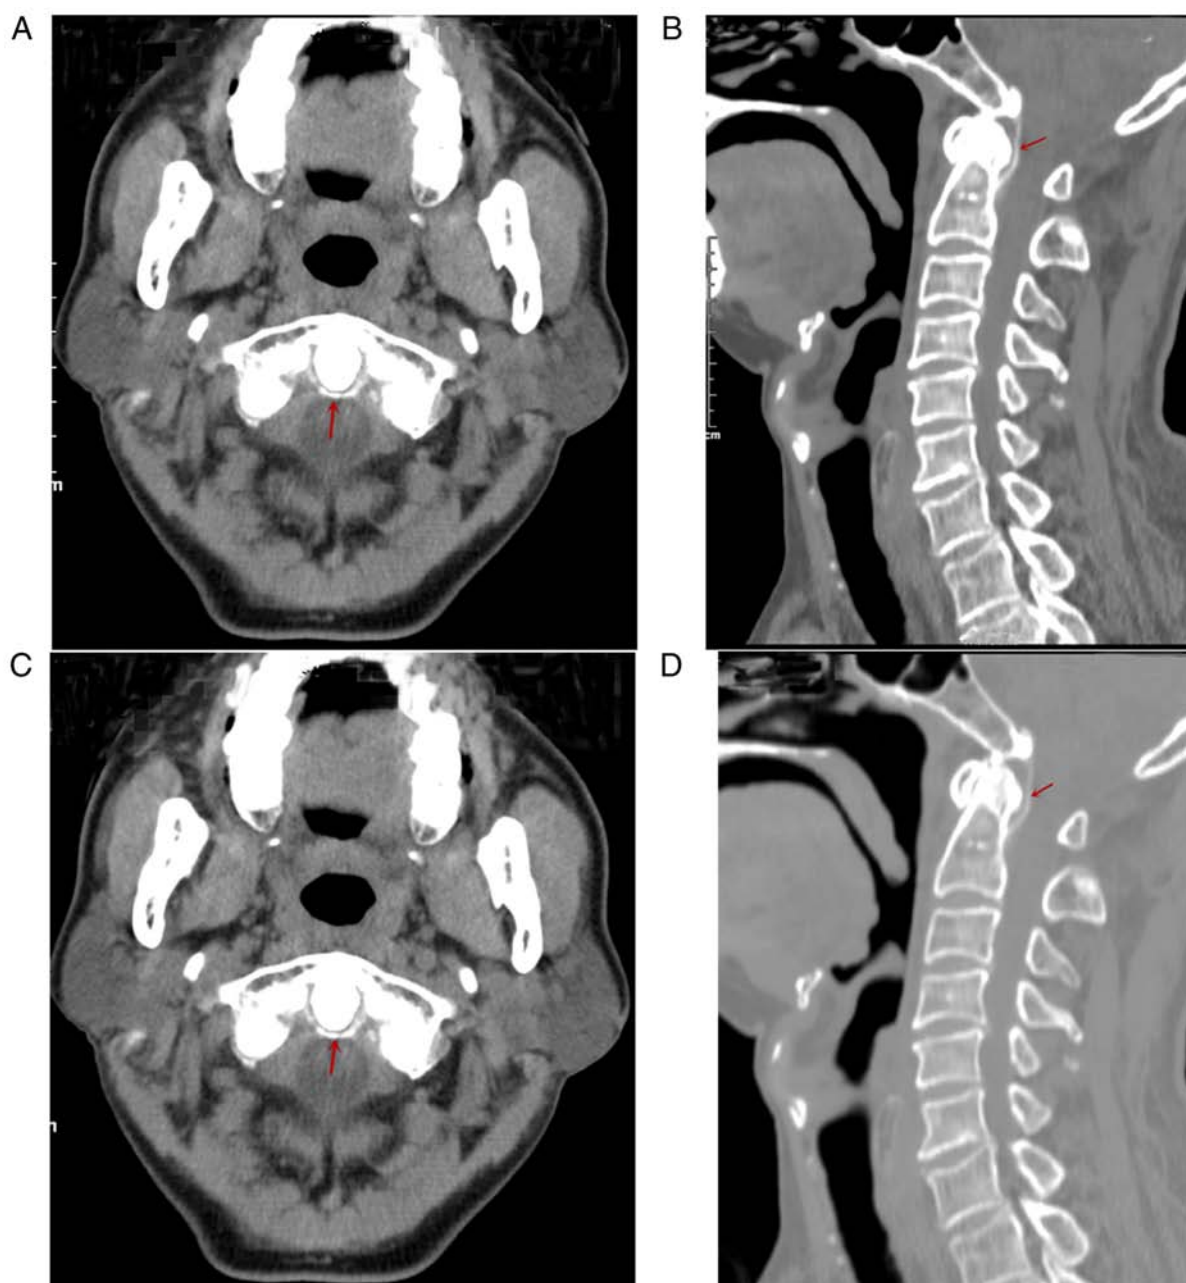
CT scans of a 70-year-old male. (A and B) CT scans at baseline revealing (A) arc-shaped calcification of the apical ligament and (B) vertical line-like calcification of the cruciate ligament in the posterior area of the odontoid process. (C and D) Follow-up CT images at 3 months displayed (C) the arc-shaped calcification of the apical ligament and (D) the vertical line-like calcification of the cruciate ligament in the posterior area of the odontoid process. Red arrows indicate the sites of calcium deposition.
